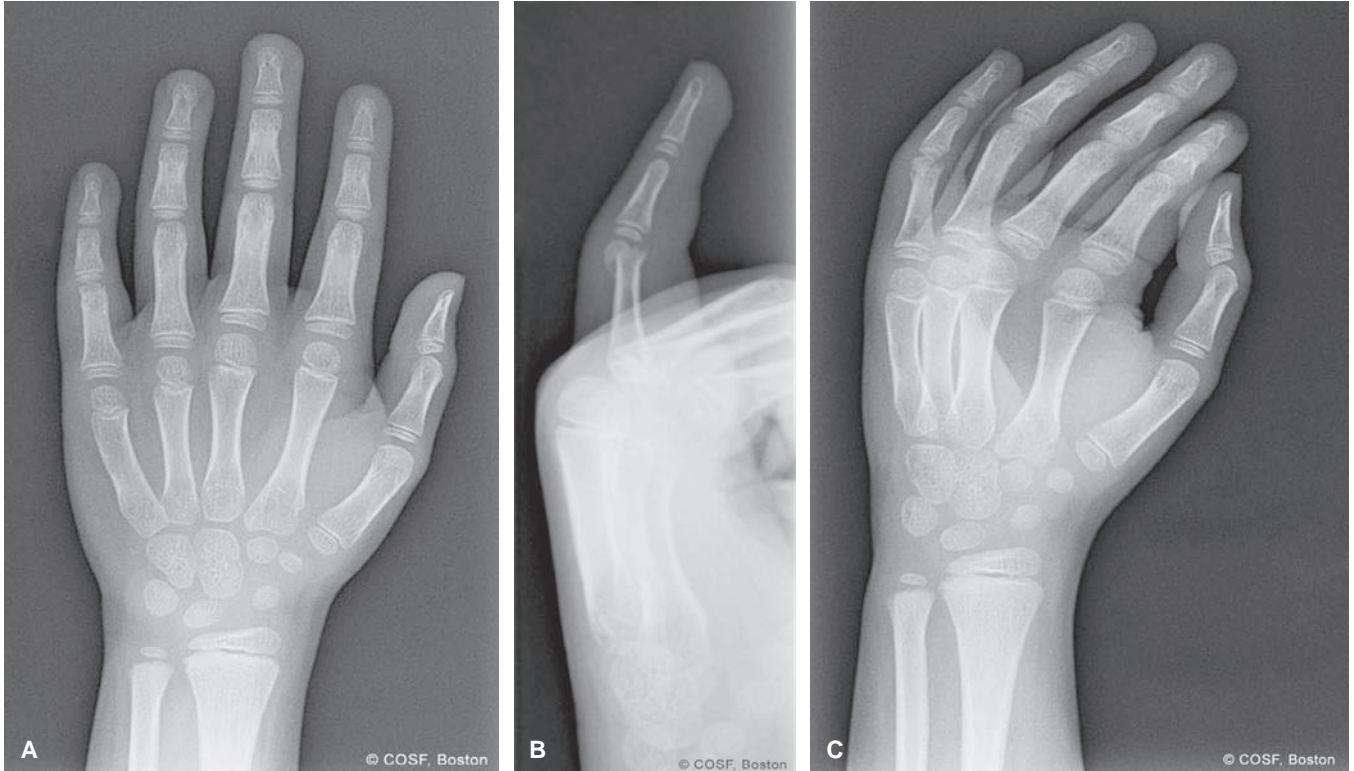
Radiographs of a displaced small finger proximal phalangeal neck fracture. Note the relatively subtle and benign radiographic appearance on the anteroposterior view (A). Fracture displacement is best seen on a dedicated lateral view (B) as well as on oblique projections of the small finger (C). (Courtesy of Children’s Orthopaedic Surgery Foundation.)
